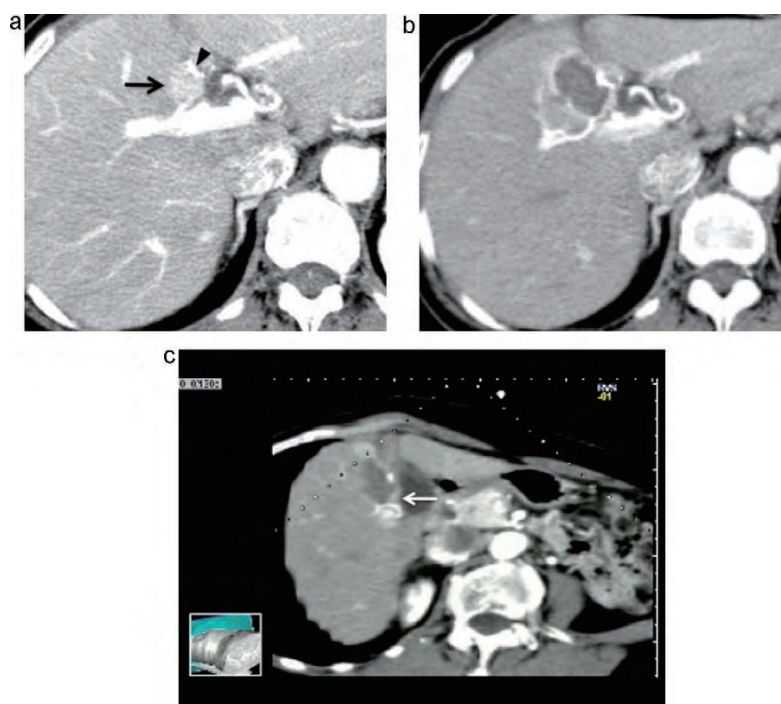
A 70-year-old man with 1.5 cm local tumor progression of hepatocellular carcinoma after transcatheter arterial chemoembolization about 1 year ago. (A) Early phase dynamic CT scan shows local tumor progression of hepatocellular carcinoma as enhanced lesion (arrow) in segment 4 of liver. Iodized oil accumulated spot was depicted in touch with viable hepatocellular carcinoma (arrowhead). (B) Axial CT scan of early phase obtained two days after radiofrequency ablation therapy shows that thin enhancement around the ablated area could be caused by hyperemia. (C) Virtual CT sonography obtained from the same CT volume data of Fig. 1B shows a circular enhancement portion (arrow) by oblique dimensional assessment. Left bottom: plane against the body trunk shows the transducer angle.
